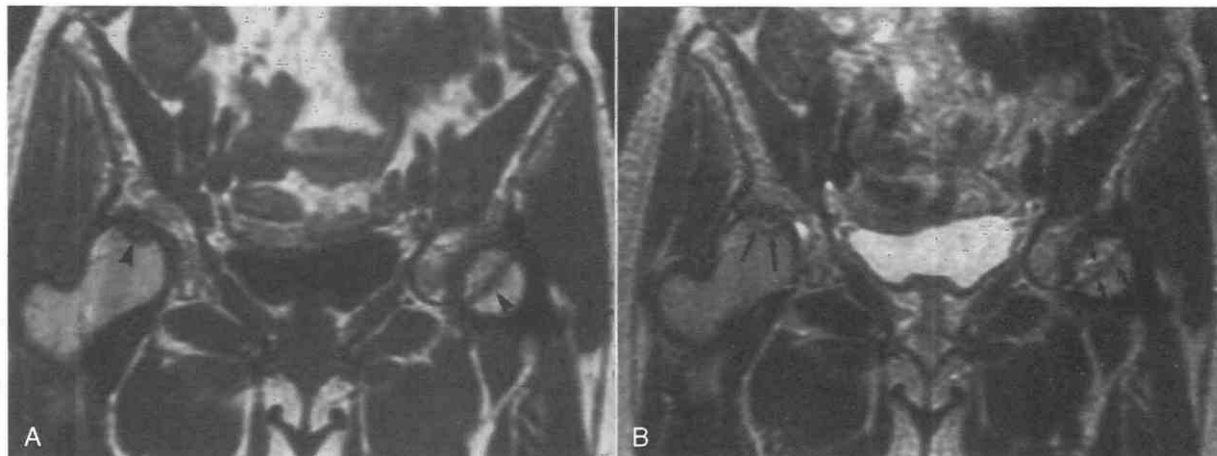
Avascular necrosis (AVN) of both femoral heads in a 41-year-old patient receiving steroids for long-standing systemic lupus erythematosus. A, Coronal T1-weighted MR image shows focal crescentic areas of decreased marrow signal typical of AVN in both femoral heads (*arrowheads*). B, Coronal T2-weighted MR image shows linear high signal intensity band (*small arrows*) with a persistent low-signal-intensity rim (*large arrows*), consistent with the *double line sign*, characteristic of AVN on the right. The area of AVN on the left has fat-like signal intensity typical of class A changes, and predominantly low signal intensity on the right (fibrous tissue), typical of class D changes.
